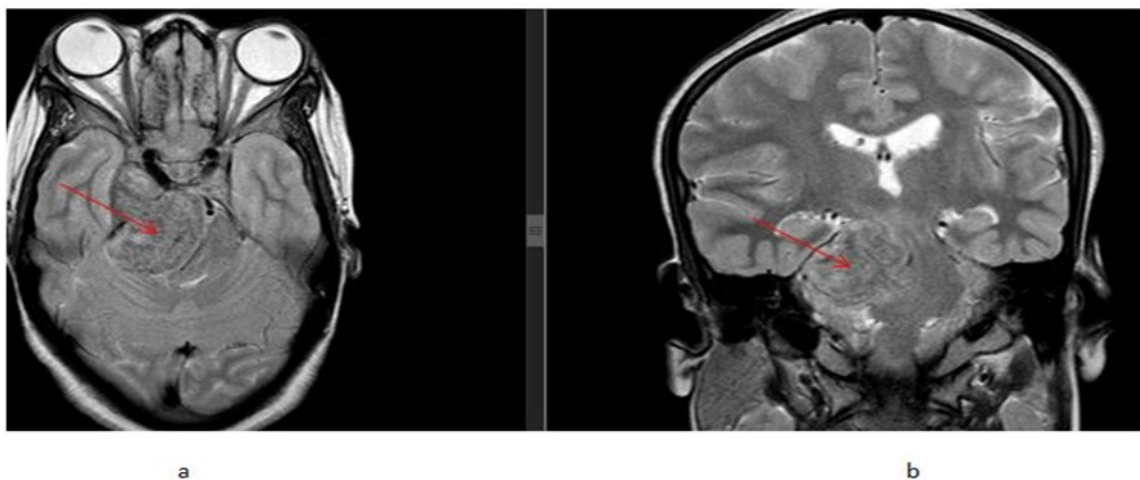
T2 brain MRI, (a) axial and (b) coronal planes showing right side multicompartmental extraaxial dural based hypointense masses (red arrows) in the right prepontine cistern, Meckel's cave and parasellar regions
